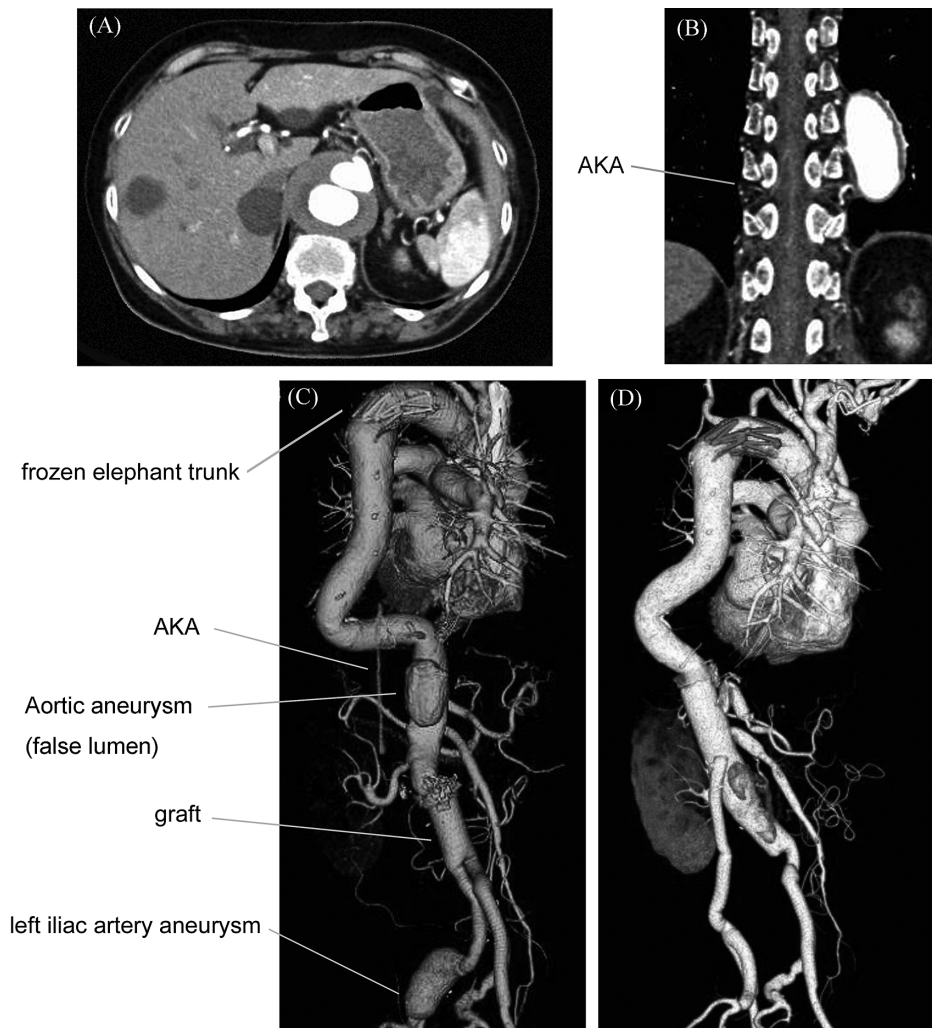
This preoperative computed tomography (CT) scan shows chronic aortic dissection. The diameter of the aorta is 55 mm including an ulcer-like projection (A). This preoperative CT scan shows the Adamkiewicz artery communicating with the left intercostal artery of Th10 (B). This preoperative 3-dimensional CT scan shows the aortic arch, which was previously repaired with a frozen elephant trunk; the abdominal aorta, which was previously repaired with a graft; the left iliac artery aneurysm, the thoracoabdominal aortic aneurysm, and the Adamkiewicz artery (C). This postoperative 3-dimensional CT scan shows successful aortic reconstruction (D).
